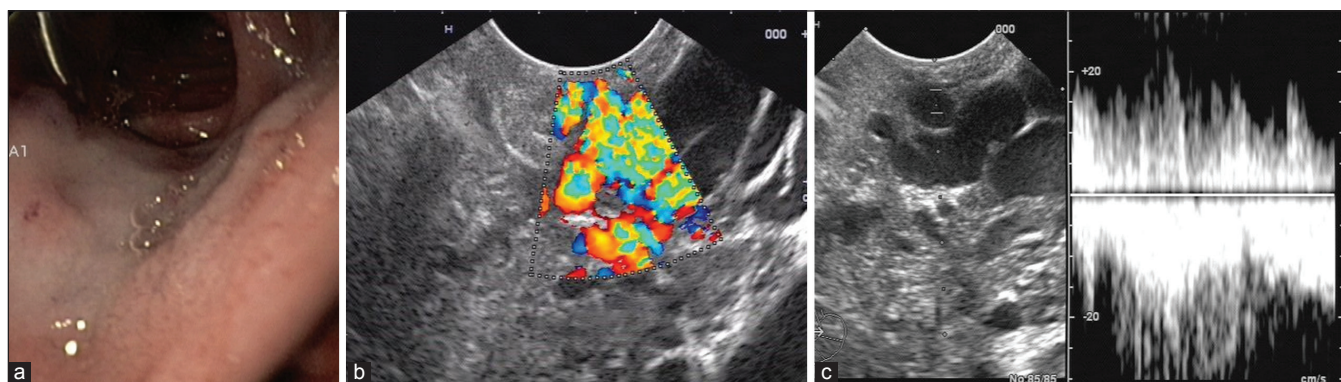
(a) Endoscopic image showing a submucosal lesion with a hemoclip; (b) endoscopic ultrasound (EUS) with color Doppler showing duodenal varices with collaterals; (c) EUS with pulse Doppler showing venous waveform
